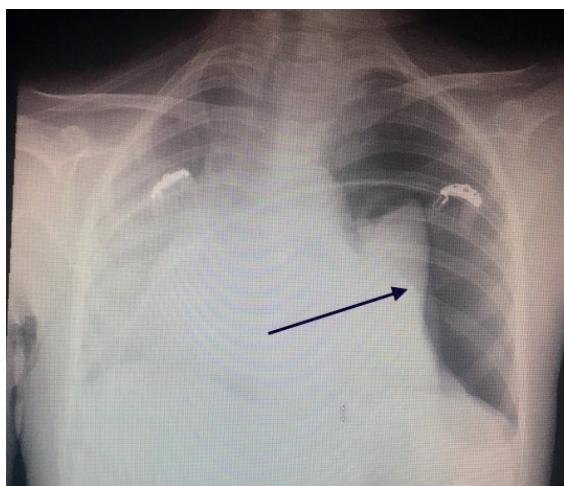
Posteroanterior chest X-ray showing pneumothorax on the left side.
